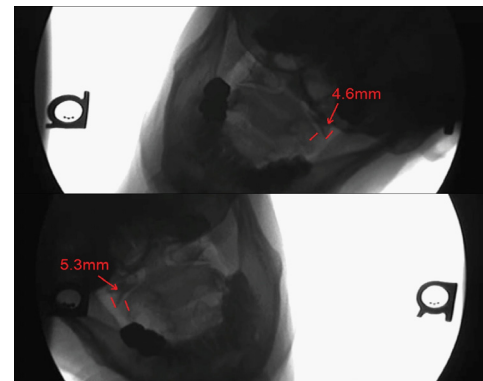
Digital motion x-ray demonstrating severe bilateral atlantoaxial (C1-C2) instability with open mouth view and lateral neck flexion.
